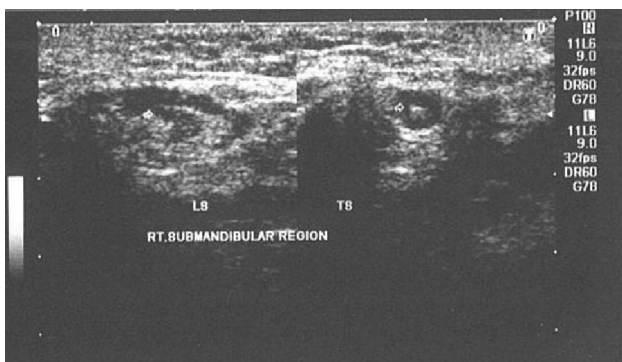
Ultrasound in longitudinal (LS) and transverse (TS) axis of right submandibular region showing dilated Wharton's duct with echorefective calculus (marked by arrow) in medial portion of remains of Wharton's duct. (Previous history of removal of right submandibular salivary gland).
